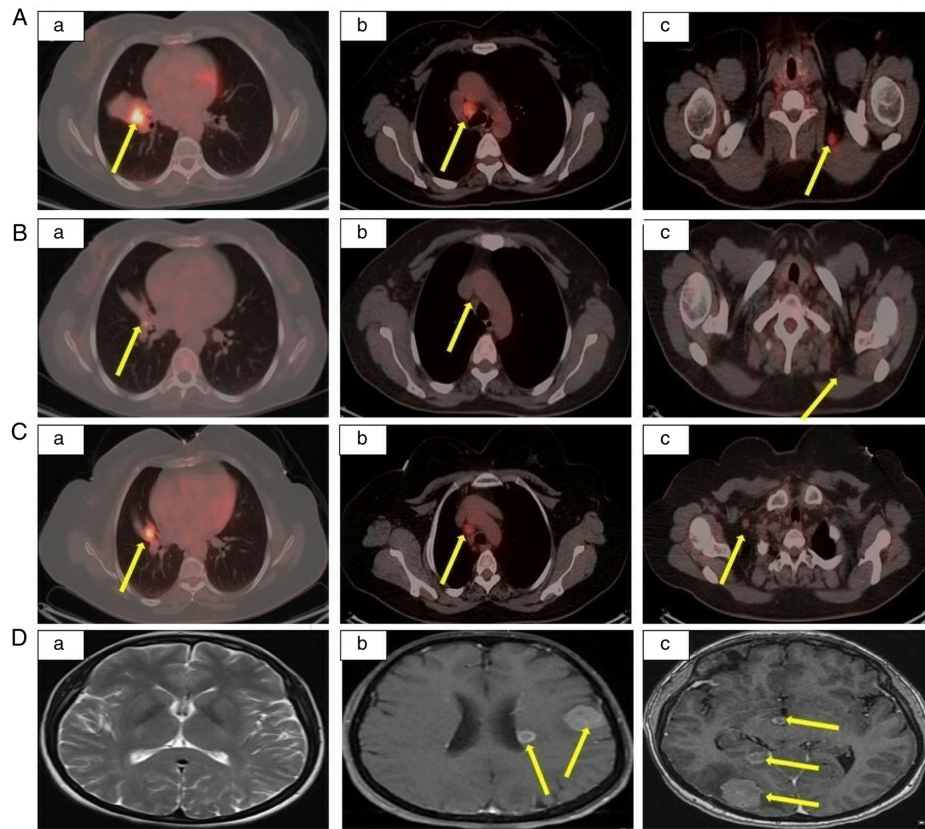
Radiological appearance at diagnosis, complete response and recurrence. PET-CT images of the diagnosis of (Aa) lung mass, (Ab) mediastinal lymph nodes and (Ac) scalene lymph nodes. PET-CT images showing complete response of (Ba) lung mass, (Bb) mediastinal lymph nodes and (Bc) scalene lymph nodes. PET-CT images of recurrent (Ca) lung mass, (Cb) mediastinal lymph nodes and (Cc) right supraclavicular lymph nodes. Brain magnetic resonance imaging at (Da) baseline and of (Db and Dc) multiple metastatic lesions on T1-weighted images. Yellow arrows indicate relevant radiological features. PET-CT, positron emission tomography-computed tomography.
